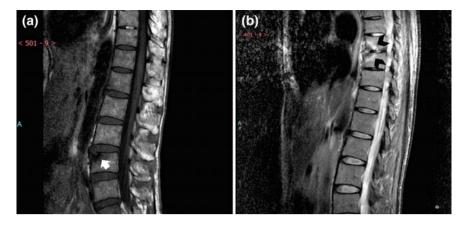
Spine abnormalities on magnetic resonance imaging in a patient with ankylosing spondylitis. Sagittal view of lumbar spine. a Erosion of the anterior portion of a lumbar vertebral body (*arrow*) is shown as hypointense signal in T1 weighted image. b Erosions and osteitis (*arrowheads*) on adjacent vertebral bodies is shown as hyperintense signal on a STIR weighted image
